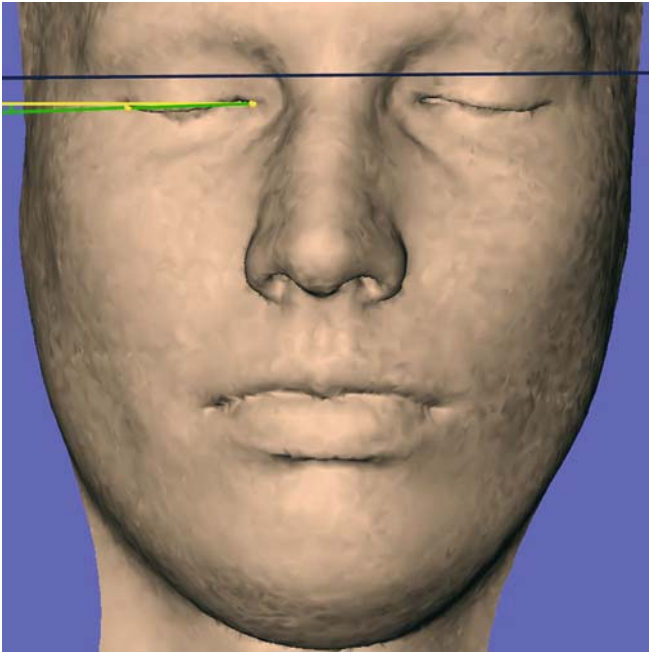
The inclination of the right eye-fissure from the horizontal plane, ex_r-en_r / x -plane, is a projected angular soft tissue measurement on the vertical (y) 3-D cephalometric reference plane (3-D CT, soft tissues, patient K.C.)
